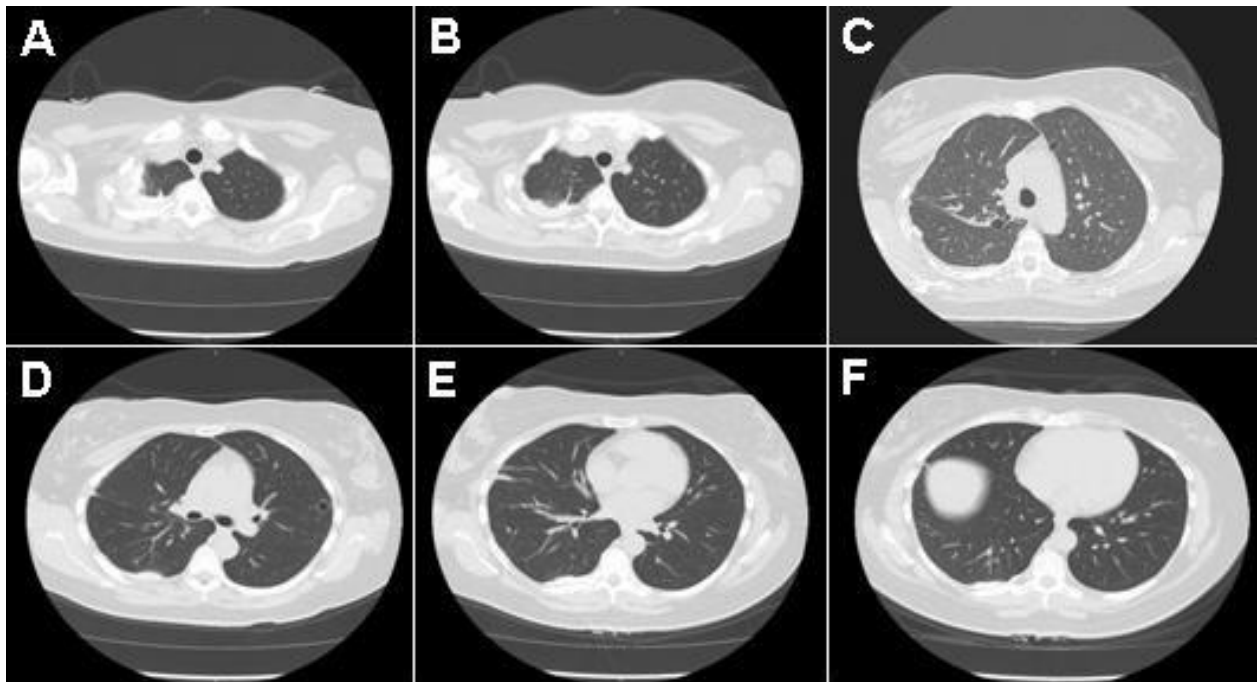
Representative images from January 2019 high resolution thoracic CT scan in lung windows.
